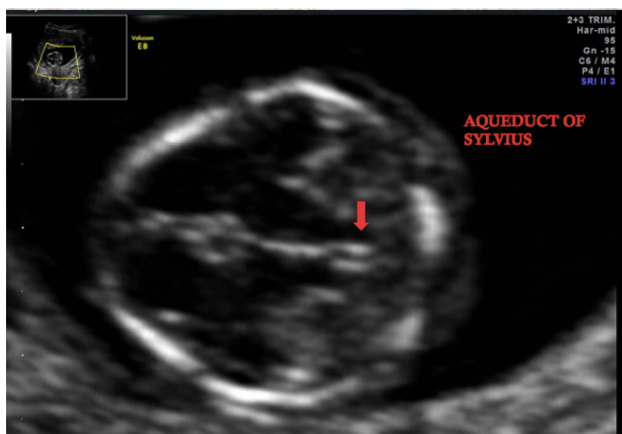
Ultrasound image showing the aqueduct of Sylvius (*red arrow*)
